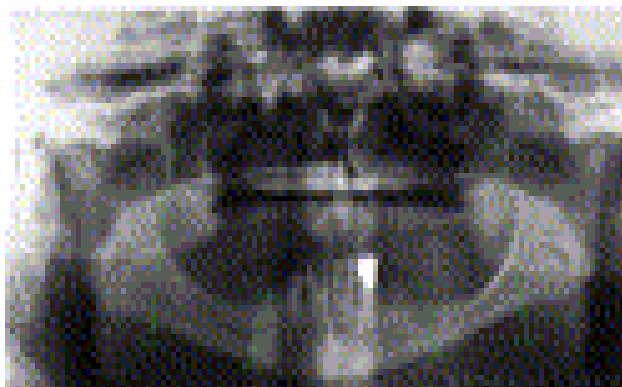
Panoramic radiograph showing the sites most affected by bone resorption in an osteoporotic patient (M. SIDQUI).
